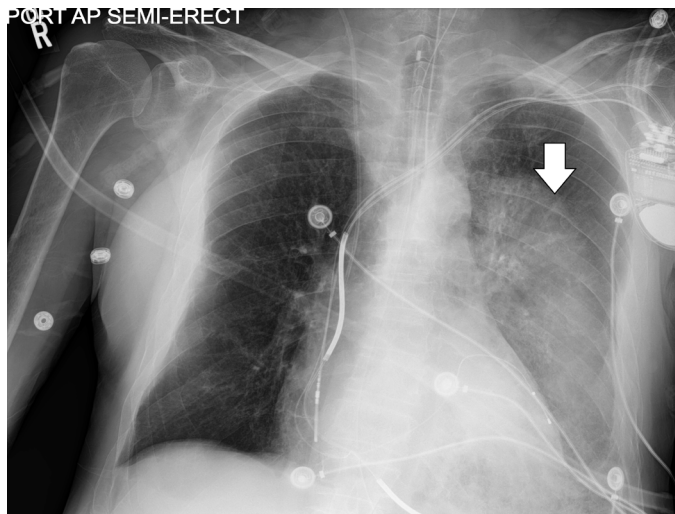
The follow-up anterior-posterior chest radiograph following the patient's clinical decompensation demonstrating a rapidly worsening left lower lobe infiltrate (arrow).
